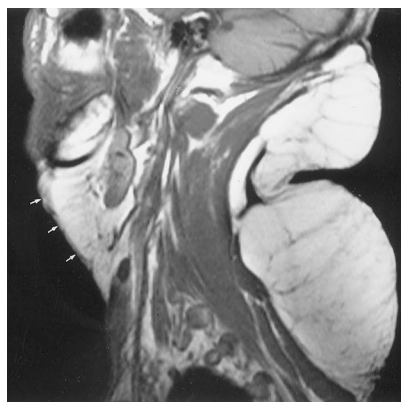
Sagittal T1-weighted MR image (500/20) shows excess fat in the neck posteriorly and in the submental, submandibular space anteriorly (arrows).
